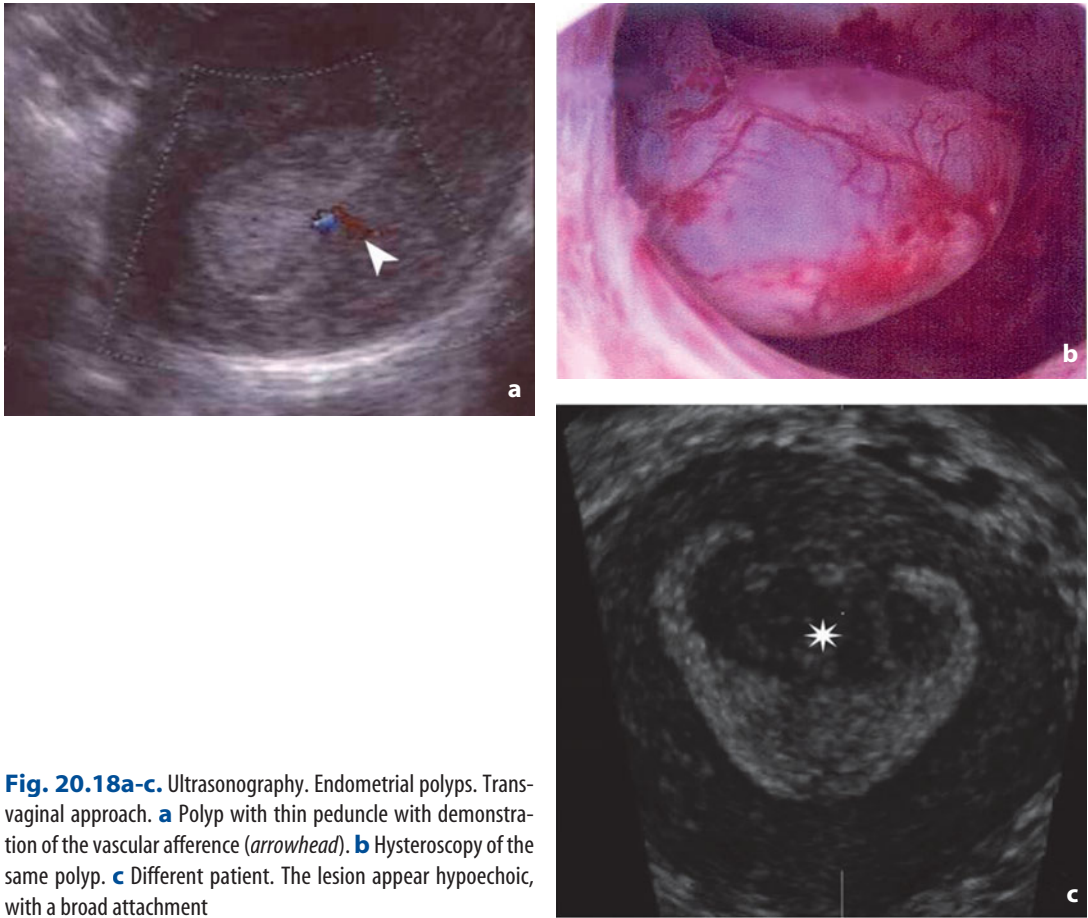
Ultrasonography. Endometrial polyps. Transvaginal approach. a Polyp with thin peduncle with demonstration of the vascular afference (*arrowhead*). b Hysteroscopy of the same polyp. c Different patient. The lesion appear hypoechoic, with a broad attachment
